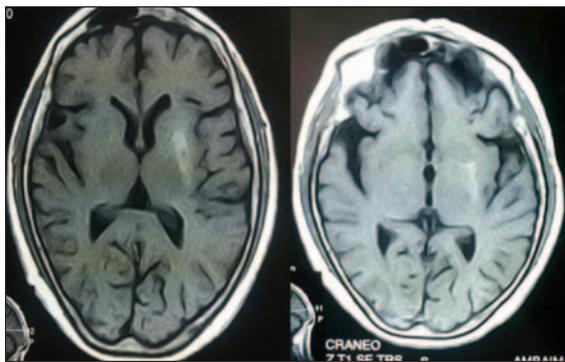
T1-weighted MRI that shows a hyperintense lesion in the left globus pallidum in a patient with NK-HCB 2 weeks after symptom onset (left) and persistence of the pallidal hyperintense lesion in the same patient at 5 months of follow-up (right).
